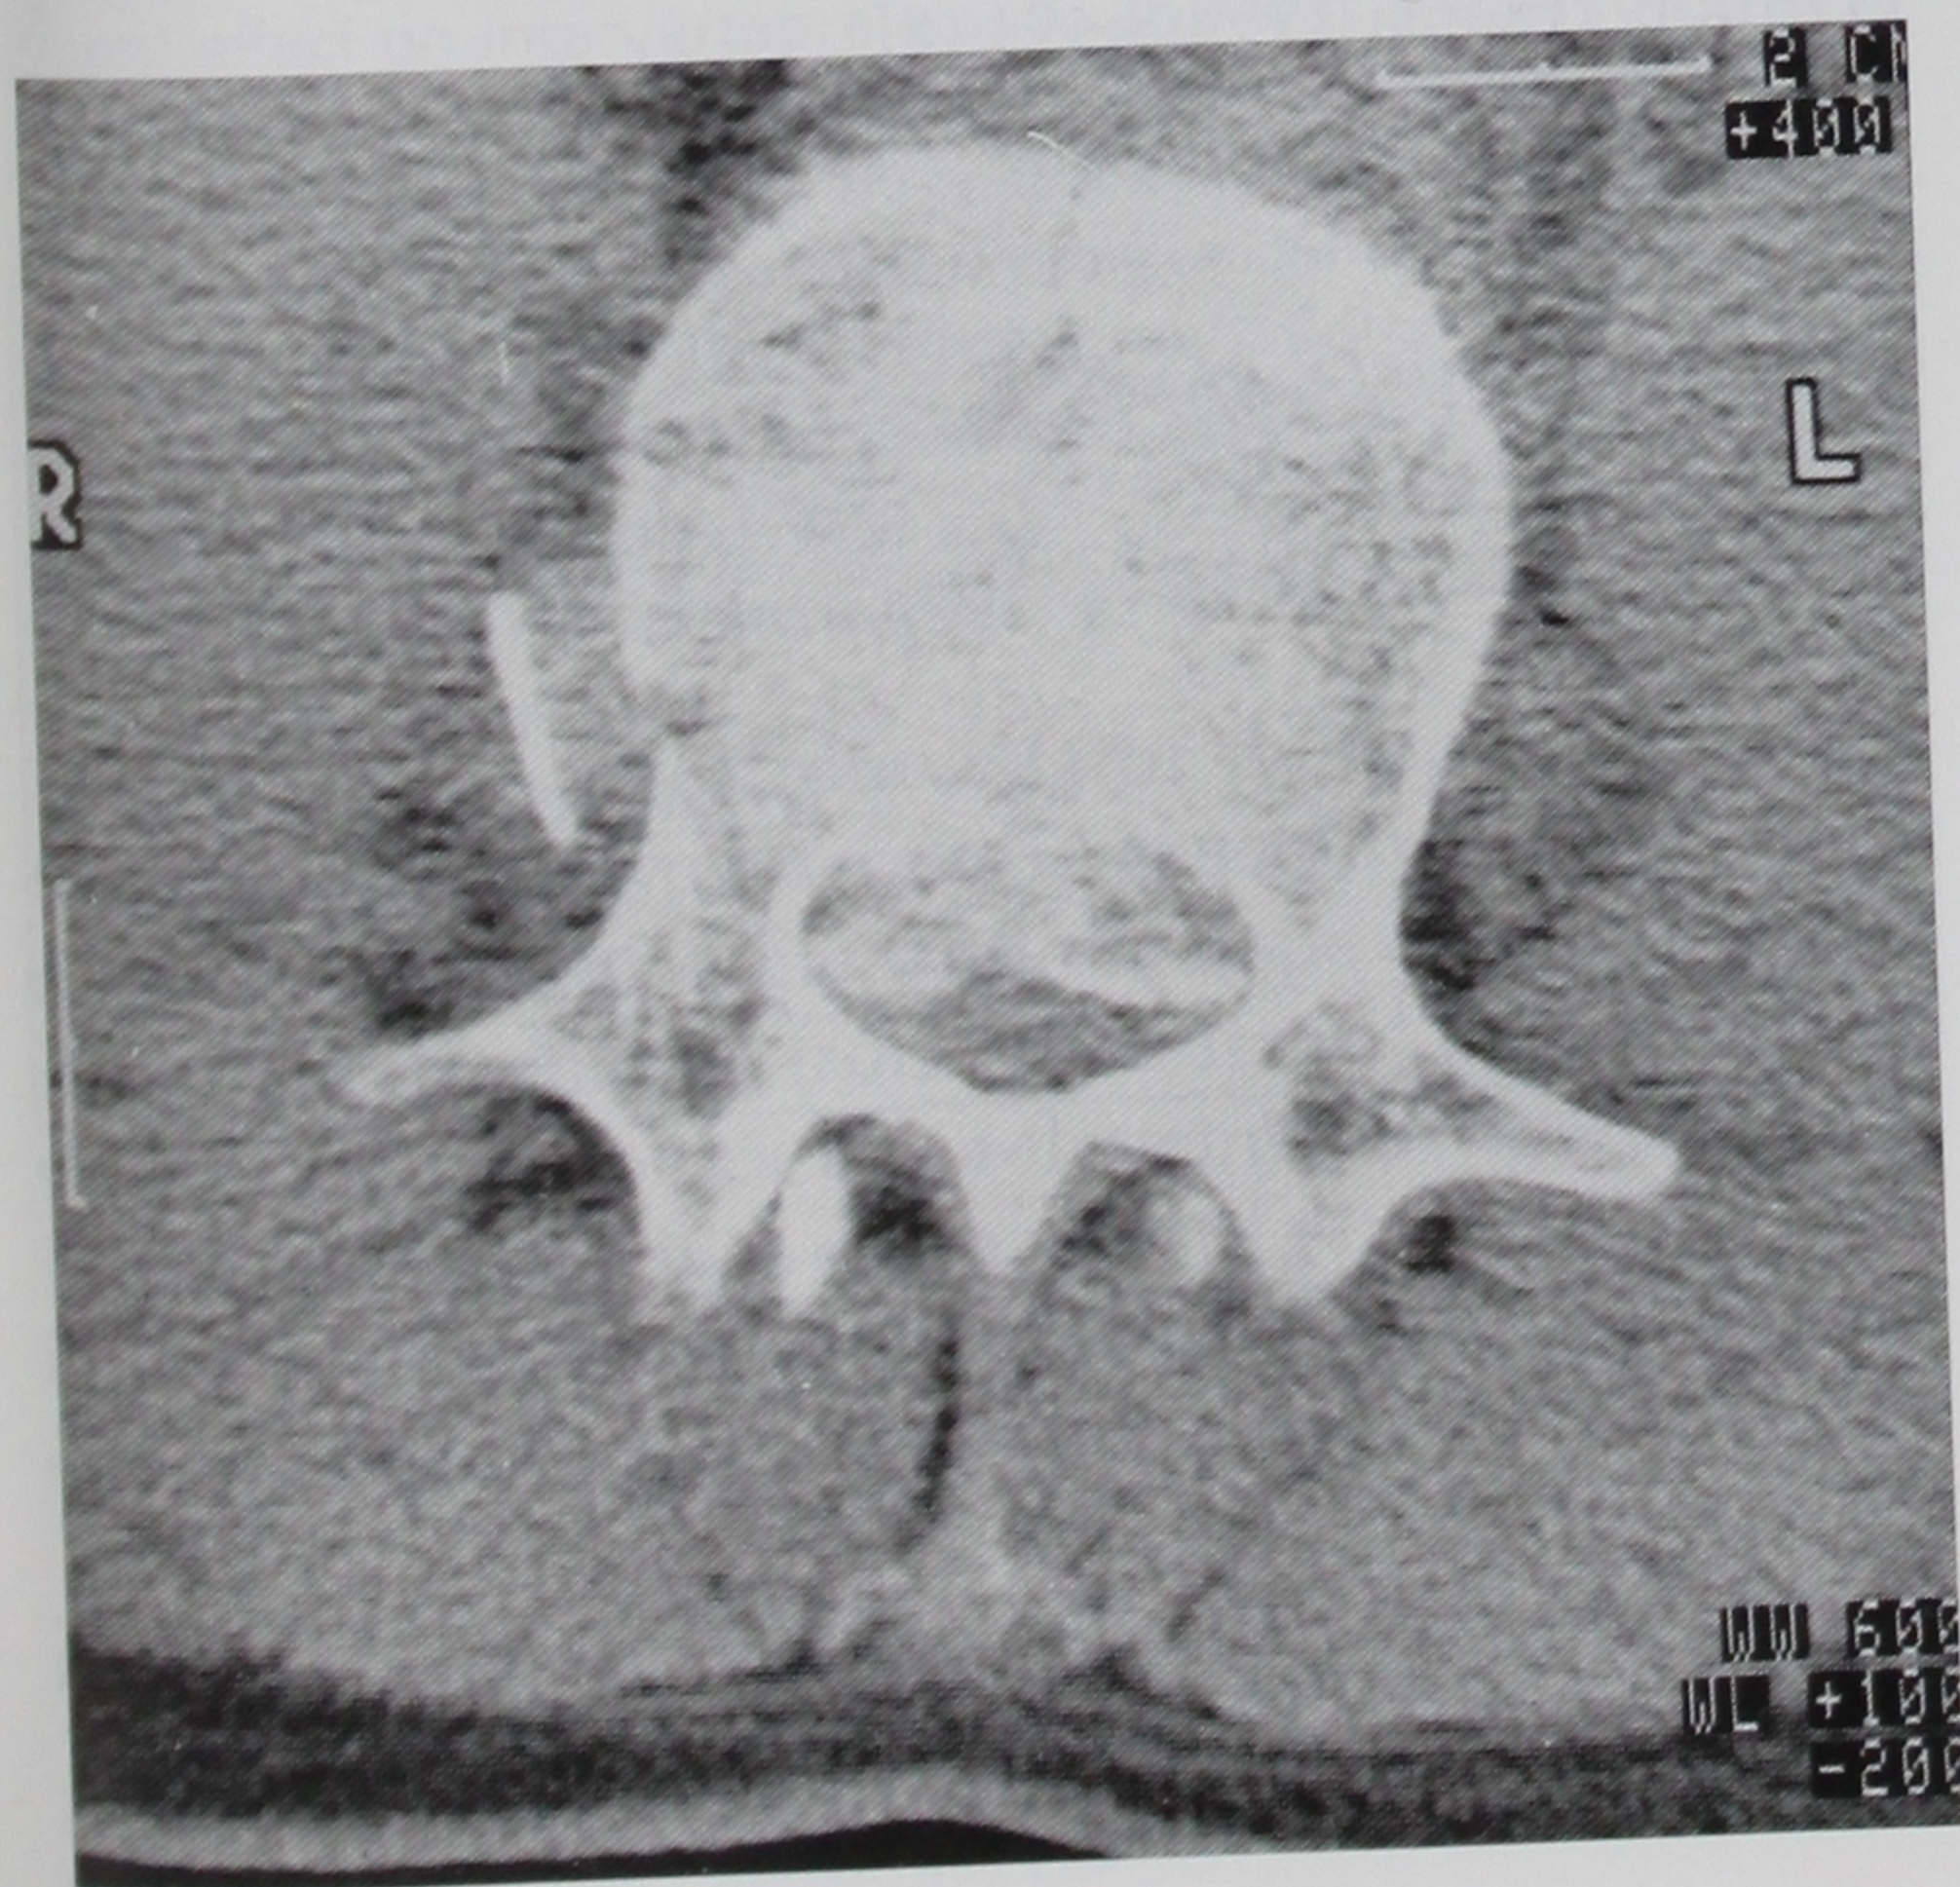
Computed tomography scan of a 33-year-old man with a burst fracture of L2, 6 hours after injury.
